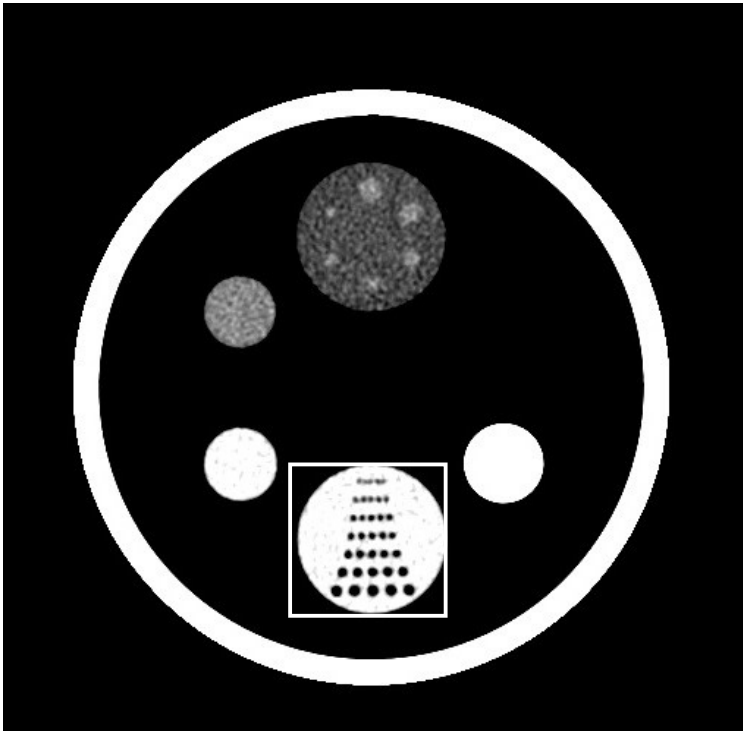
CT high contrast resolution
